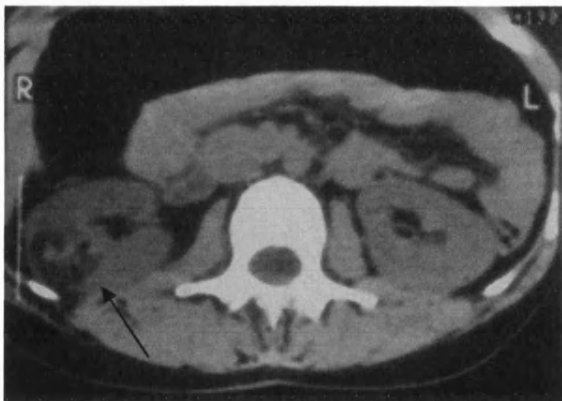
Figure twelve – Single renal angiomyolipoma (arrowed) (CT scan)
